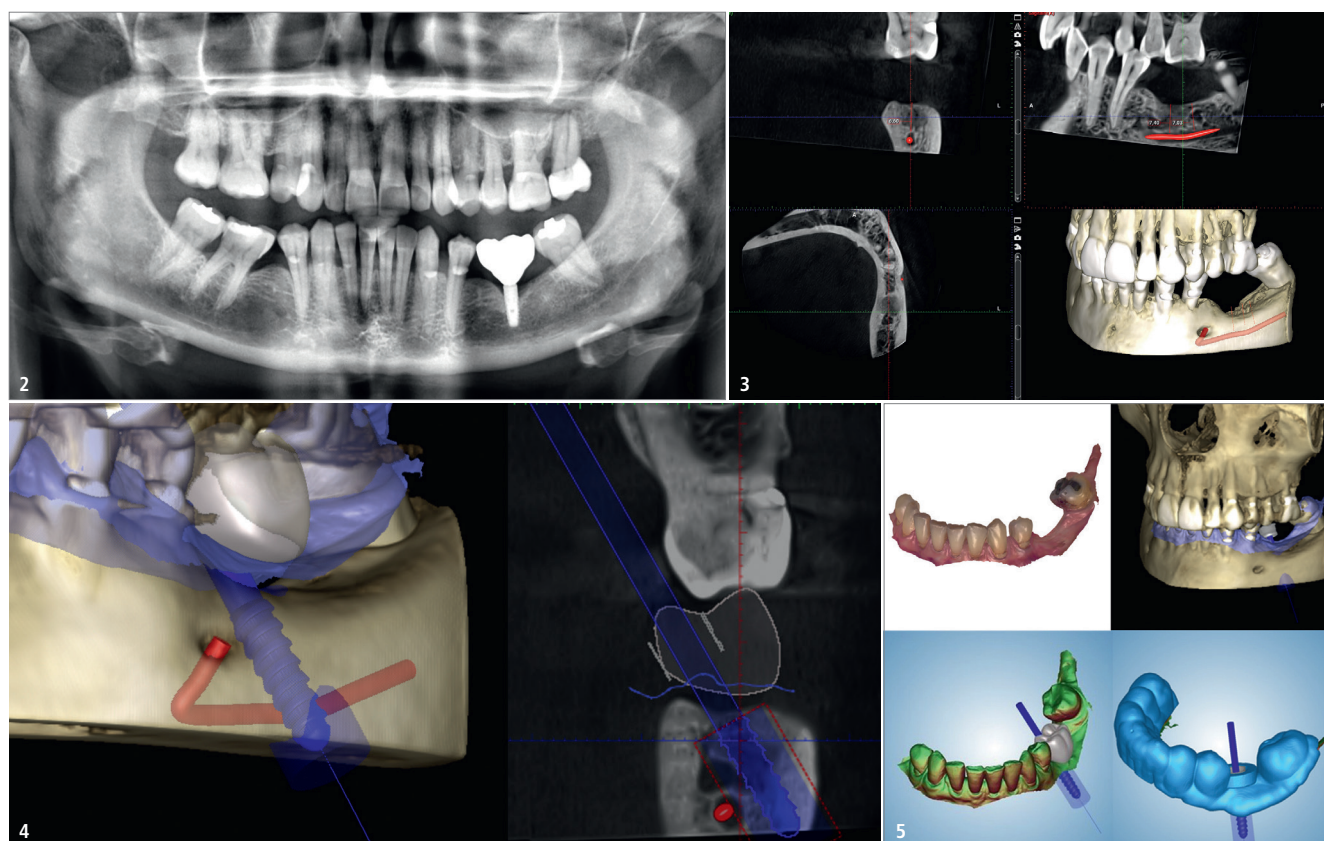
Initial radiograph before the start of treatment. – Fig. 3: CBCT scan three months after implant removal. – Fig. 4: Planned position of the BioniQ® implant near the mandibular canal. – Fig. 5: Design of a surgical template in the Romexis program, taking into account the requirements for implant position as well as a suitable restoration.
